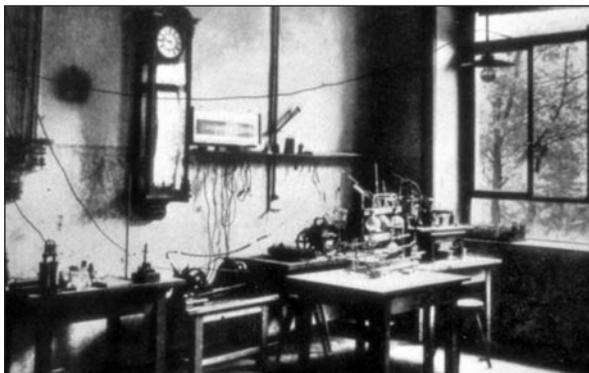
Professor Wilhelm Conrad Roentgen's laboratory at University of Würzburg where X-ray was discovered
